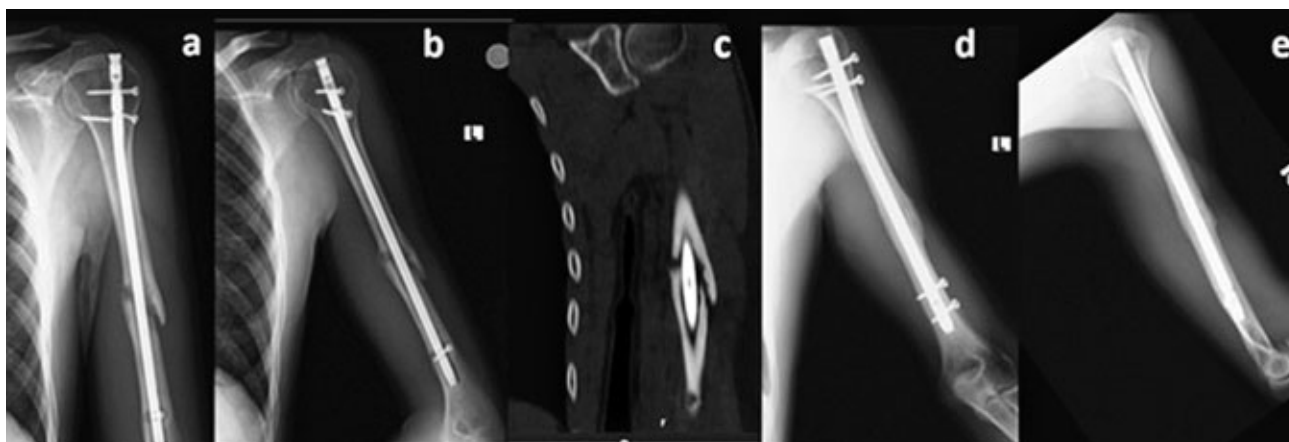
a–e. A 22-year-old man, fracture of the humeral diaphyses. Six months after locked intramedullary nailing, evidencing radiographic lack of callus formation, and loosening of the IM nail (a, b). CT view shows atrophic nonunion (c). Five-month follow-up showing radiographic bony union (d, e).
